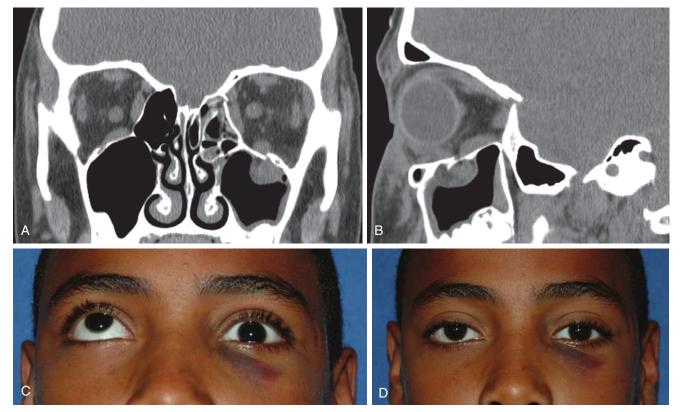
Orbital floor trapdoor fracture with entrapped muscle. A, Coronal CT view of left inferior rectus muscle entrapped. B, Sagittal CT view of left inferior rectus muscle entrapped. C, Left-sided limited upward gaze. D, Left-sided enophthalmos and vertical ocular dystopia.
